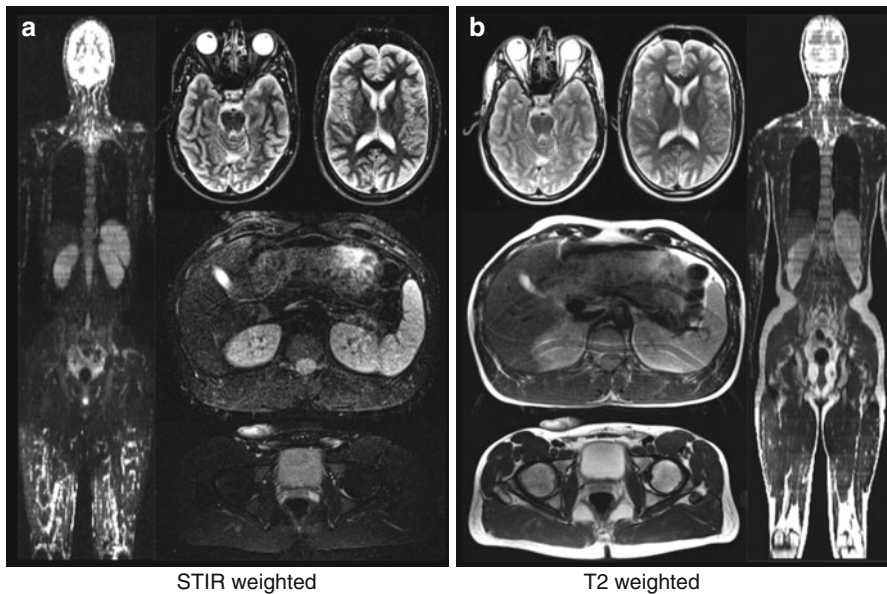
Whole-body MRI using continuous table movement. Images were acquired in the axial plane. Two image contrasts were acquired during table movement: STIR weighting (a) and T2 weighting (b). Taken together, the axial stacks form a whole-body dataset, which allows coronal reformation (leftmost and rightmost parts) (Courtesy of Dr. Gregor Sommer, Dr. Hans-Peter Fautz, Dr. Ute Ludwig, and Prof. Jürgen Hennig, University of Freiburg, Germany)
